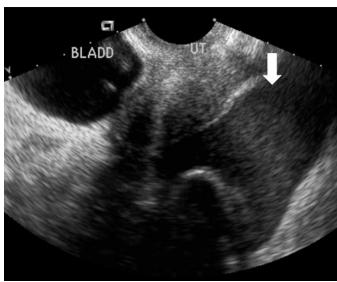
Endovaginal ultrasound image of the pelvis (longitudinal plane) demonstrating complex free pelvic fluid (white arrow) in the cul-de-sac. (UT=uterus, BLADD=urinary bladder)
